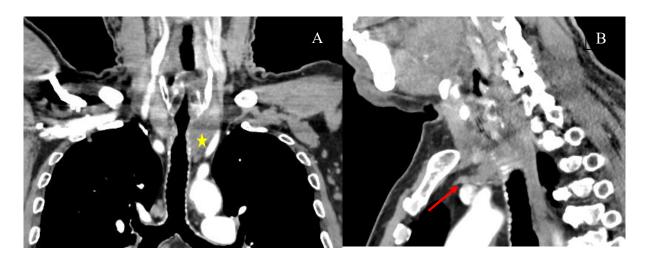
Coronal reconstruction in A and sagittal reconstruction in B of a cervico-thoracic CT scan with contrast-enhanced iodine injection.
